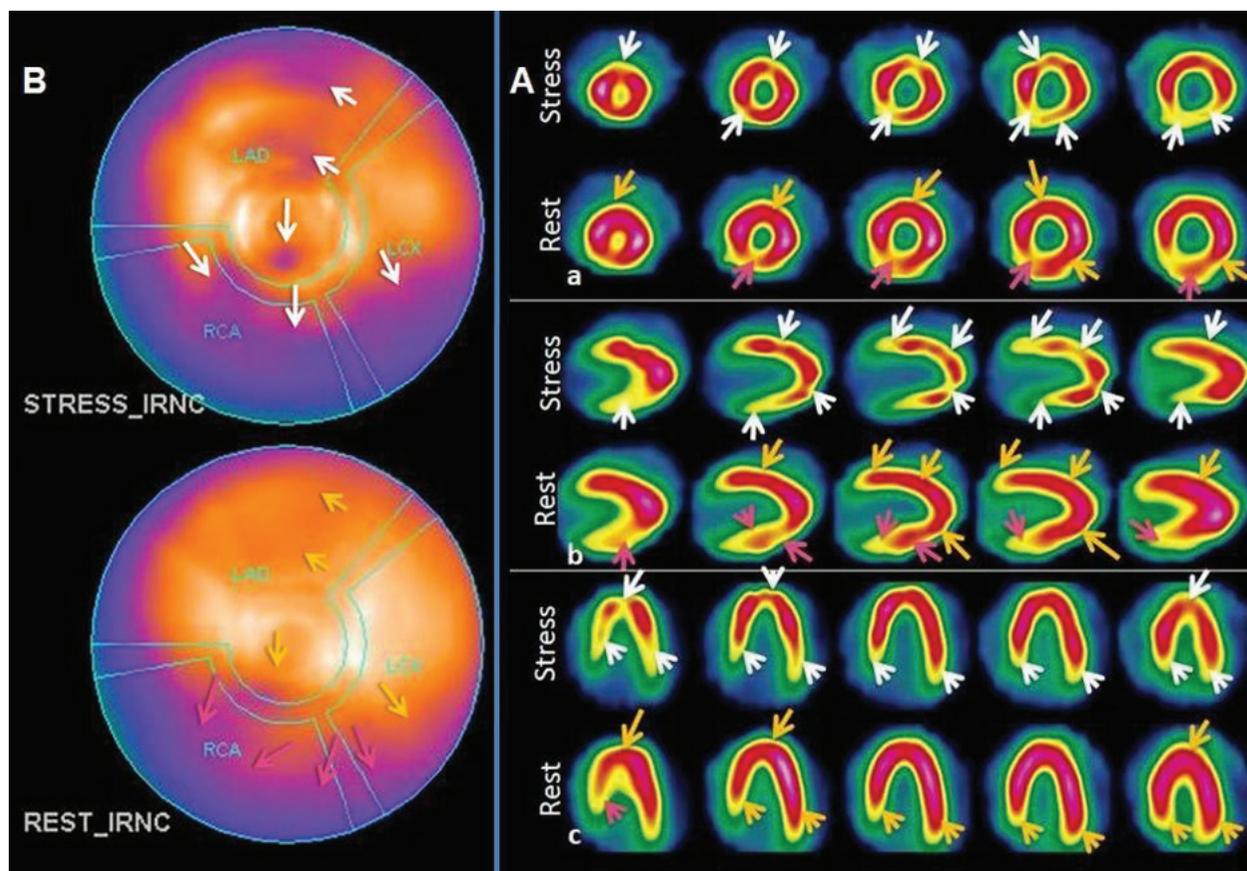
For further evaluation, myocardial perfusion imaging (MPI) was performed using a one-dimensional imaging protocol. No gated single-photon emission computed tomography was applied. Stress protocol and imaging were performed according to published guidelines and as previously reported (1). MPI results were similar to those of echocardiology, as seen in the Bulls-eye MPI image, which depicts the entire myocardium (A) and 3 axis images: a) Short axis, b) vertical axis, and c) horizontal axis (B). White arrows point to the hypoperfused areas during stress: Apical and basal anterior, inferior-septal, median, and basal areas of inferior and inferior-lateral wall, and a segment of the apical cardiac wall (seen in the center, A).
